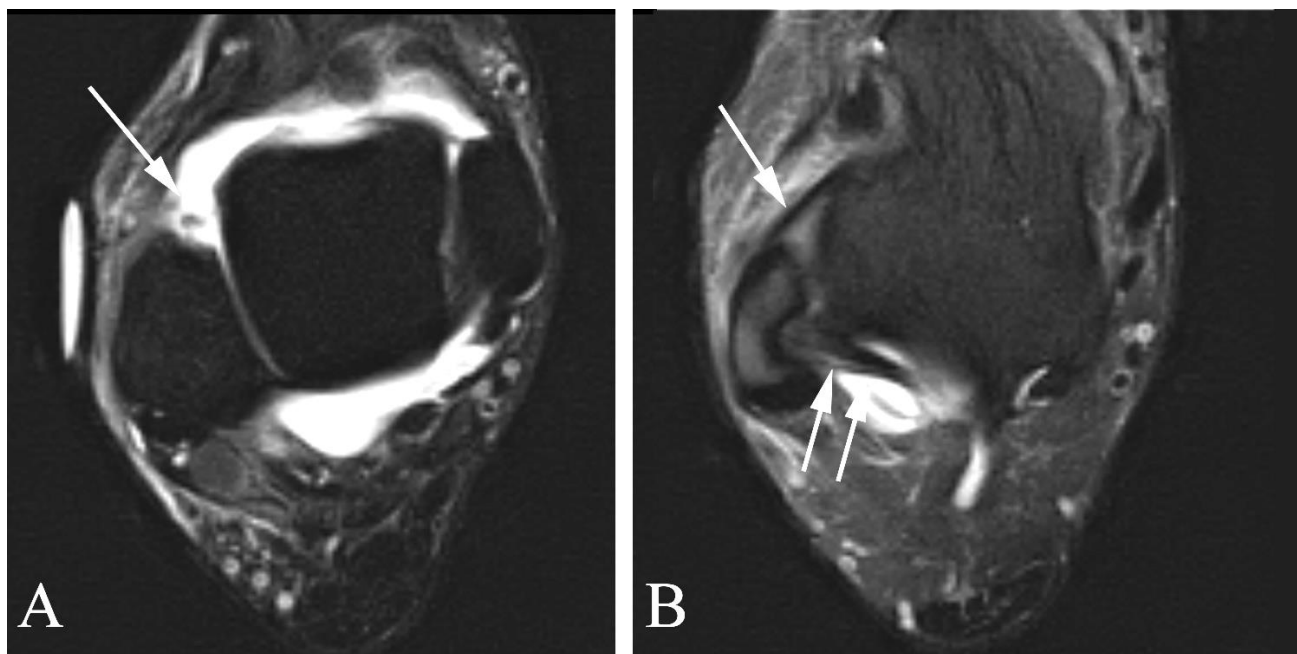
“High” ankle sprain in a 42 year old man with pain following trauma. A. Axial fat-suppressed proton density MR image shows lack of normal tissue between the distal tibia and fibula (arrow) because of a complete tear of the distal tib-fib syndesmosis. Note the large joint effusion with fluid (high signal intensity) along the anterior and posterior aspects of the talus. B. Axial fat-suppressed proton density MR image shows a normal anterior talofibular ligament (arrow) and posterior talofibular ligament (double arrow).
